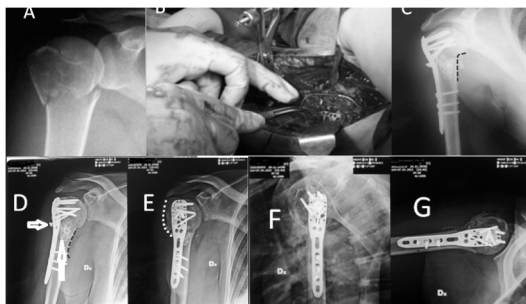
A) Three parts fracture of right proximal humerus, 53-year-old female fallen from a step, B) placement of wires and plate, C) post-surgery radiograph showed good reduction of medial inch (dotted red line) with Philos and augmentation, D) radiographs after 12 months from surgery showed the pull out of the kickstand screw (white arrow) and loss of medial inch (dotted black line), incomplete bone healing (upwards white line), E) unsatisfactory reduction of greater tuberosity (white dotted line), F, G) posterior rotation of the humeral head (Rollo G, 2014).
